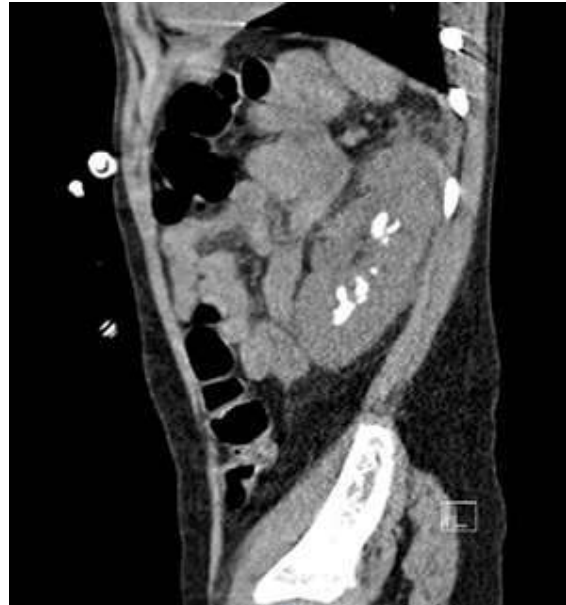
Sagittal CT scan showing multiple large non-obstructing nephrolithiasis.
